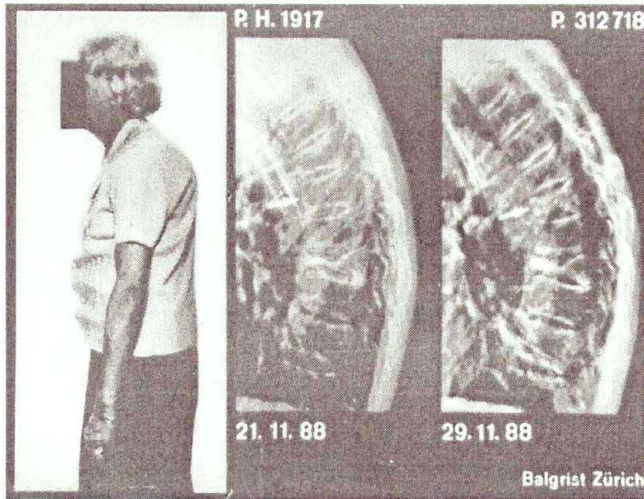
Collapse of cervical spine vertebra (arrow) due to osteoporosis in 71 year old woman (note the dates of the X-ray examinations)
